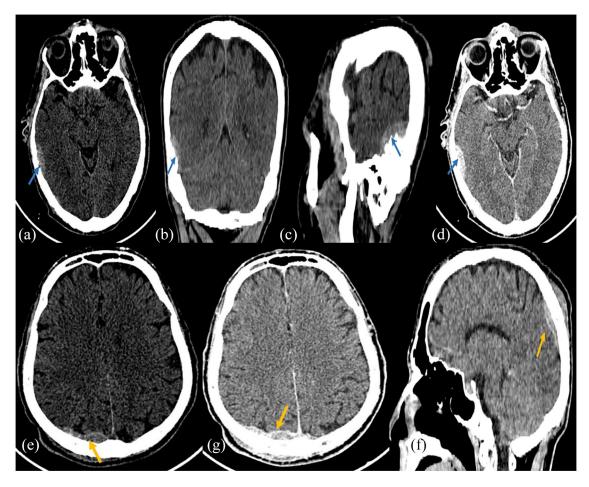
Brain CT scan showed:
